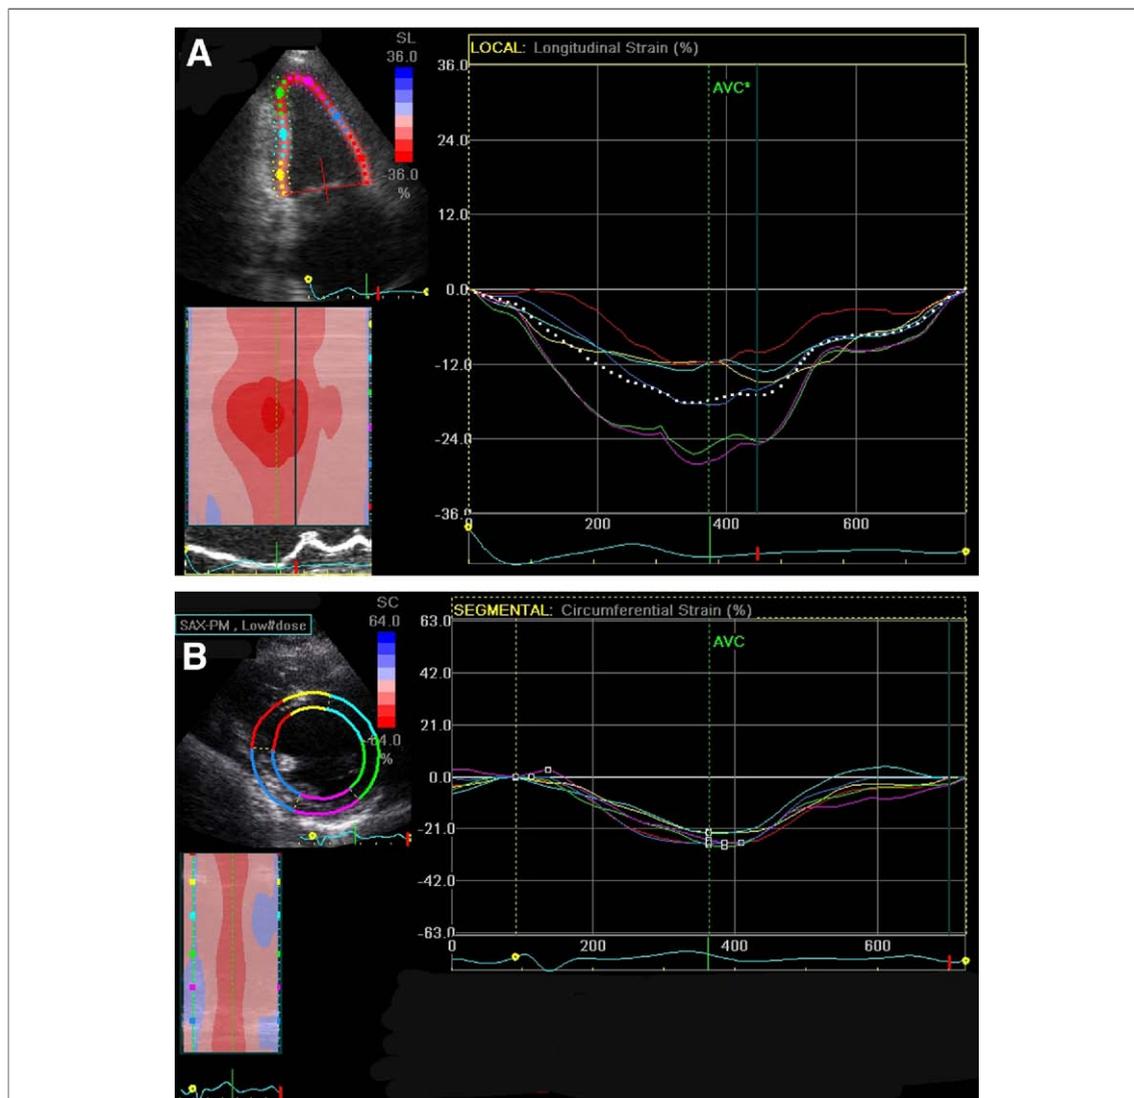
Measurement of Longitudinal (A) and Circumferential (B) Myocardial Strain Using Speckle-Tracking Echocardiography
